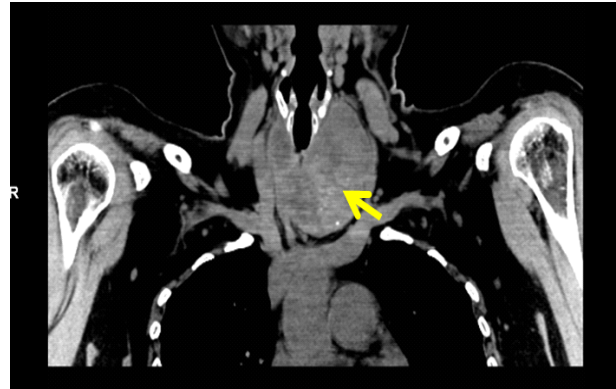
Computed tomography (coronal plane): left thyroid and isthmus macronodule
